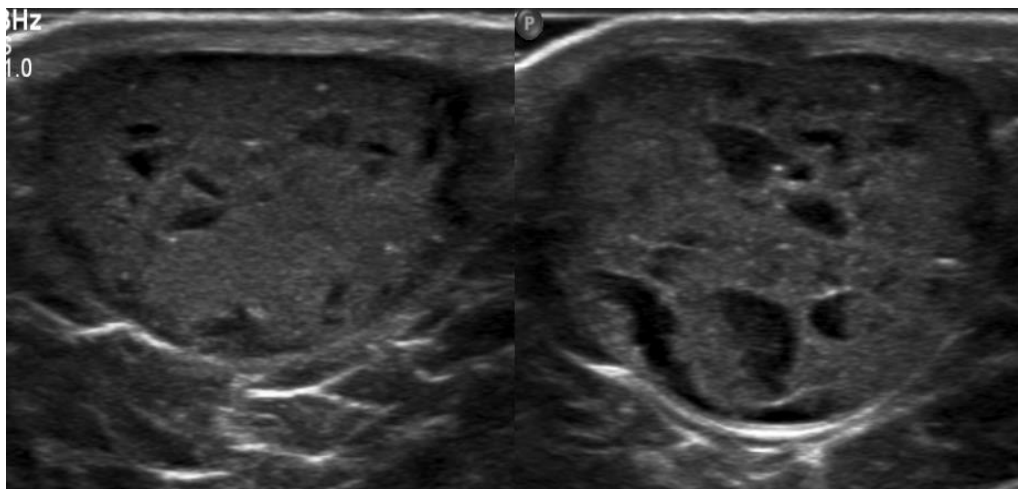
Local ultrasound of lesion mentioned in figure shows well defined ovoid lesion with filiform anechoic areas and linear hyperreflective disc like areas representing keratin, suggestive of epidermoid cyst.
